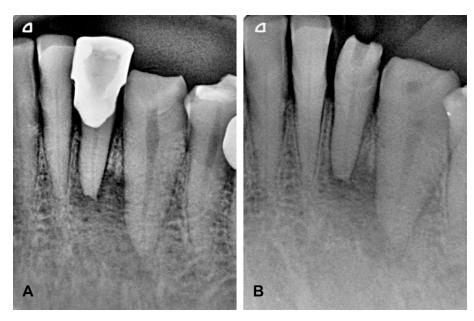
Dentoalveolar radiographs of teeth 32 and 33. A. Preoperative radiograph of teeth 32 with fenestrated crown, and 33. B. Postoperative radiograph, where intracanal medication of pure calcium hydroxide and glass ionomer was placed as a provisional coronal filling.
